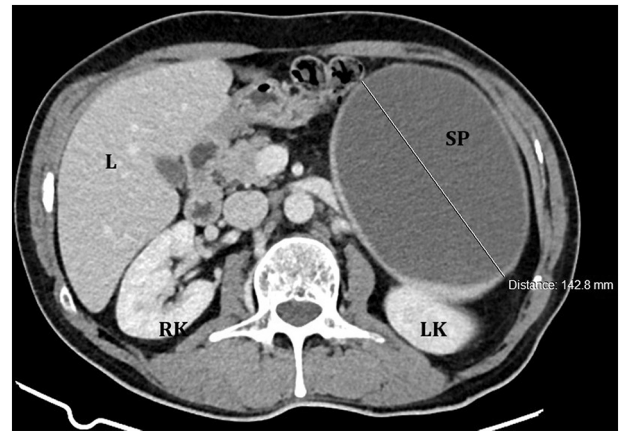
CT scan abdomen showing displaced left kidney (LK) downward by low density, a non-enhancing cystic mass of the spleen (SP).
